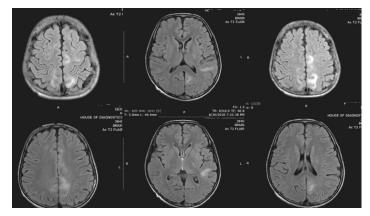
MRI brain showing hyperintensities in bilateral parietal, posterior limb of left internal capsule, left posterior temporal, and left occipital subcortical white matter regions on axial T2 FLAIR images.
